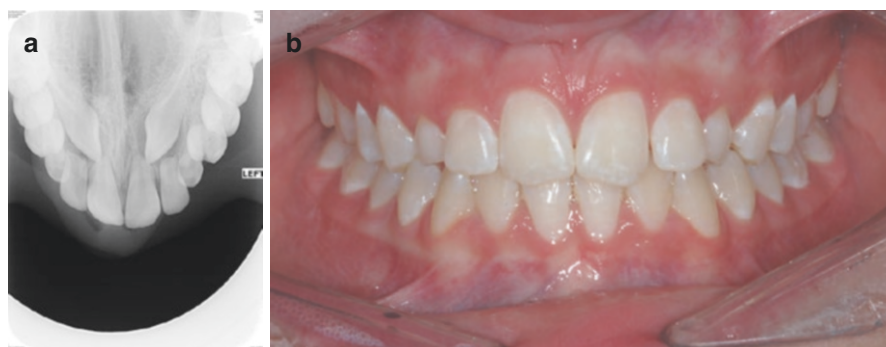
(a) Standard maxillary occlusal radiograph of a 14-year-old girl with resorbed lateral and central incisors. (b) There were no clinical signs of resorption, no discoloration or mobility of any of the incisors
